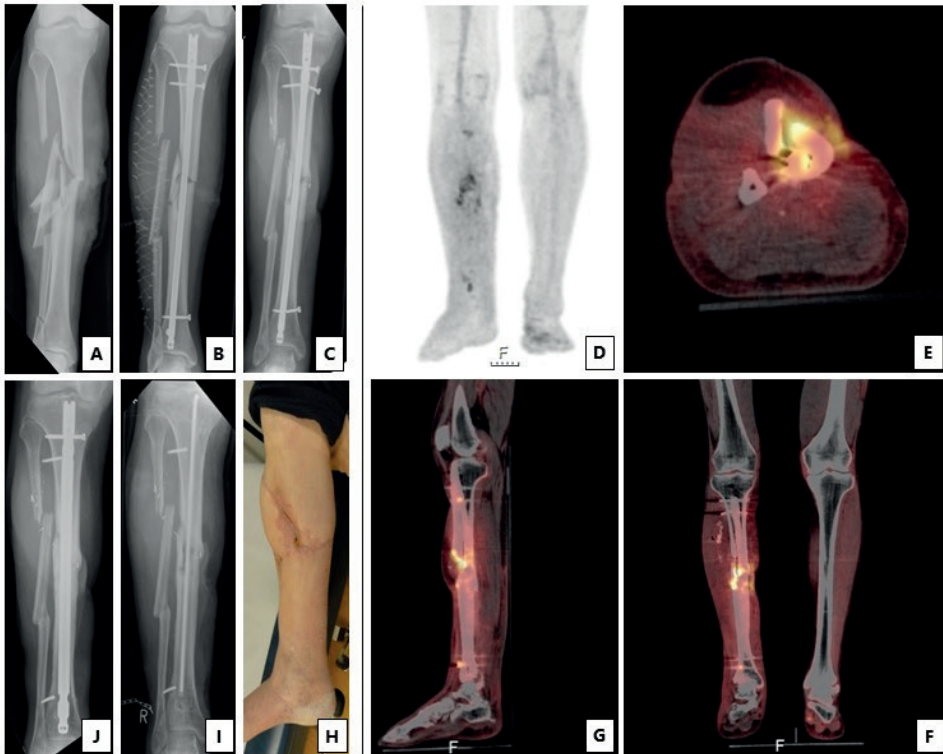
Clinical case. A 59-year-old man sustained a right sided Gustillo grade III-B open crural fracture (A) which was treated with intramedullary nailing (B) and a fasciotomy. After several soft tissue debridements, the remaining soft tissue defect was eventually closed with a free musculocutaneous flap. Twenty months later, there was a non-union with “auto-dynamisation” of the intramedullary nail, demonstrated by the broken interlocking screws (C). ^{18}F -FDG-PET scan showed increased uptake around the fracture site in the tibial shaft and around the proximal and distal screws (D). Fusion ^{18}F -FDG-PET/CT images localized the suspected fracture-related infection (FRI) to be not only at the fracture side but also in the surrounding bone of the tibia around the fracture site (E: Axial, F: Coronal, G: Sagittal) which corresponded with the unstable scar overlapping the area of the non-union (H). The intramedullary nail was removed, the tibia was reamed, the fracture site was debrided and an in-house, custom-made antibiotic nail was inserted. FRI was confirmed by microbiological cultures and the patient was subsequently treated with antibiotics. One year after exchange nailing, fracture healing was successful (J).
